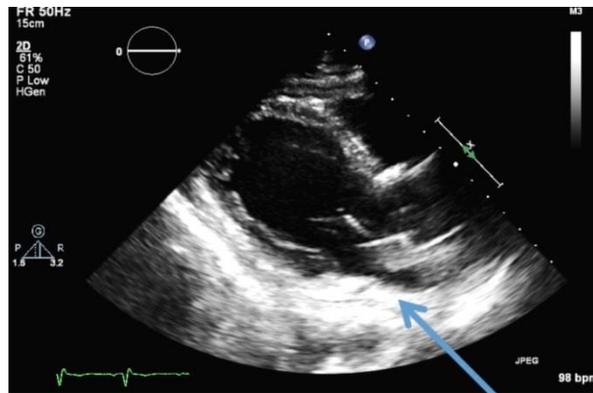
Transthoracic echocardiography post pericardiocentesis.
